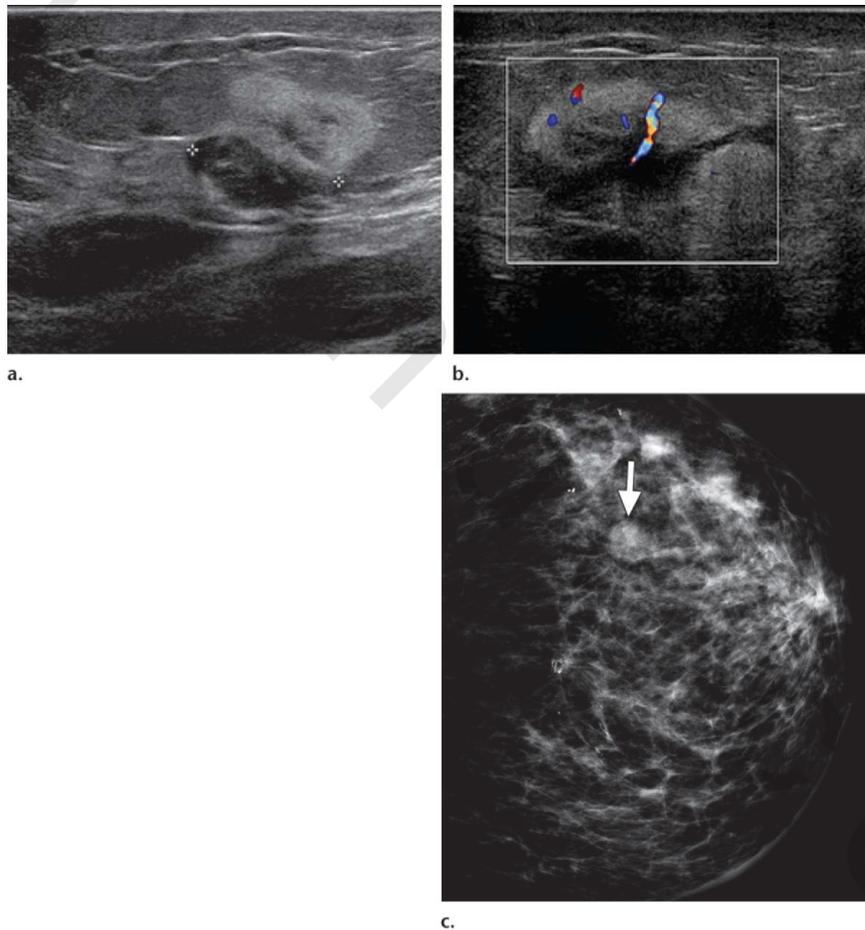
Angiosarcoma in a 64-year-old woman with a history of cancer in the left breast, lumpectomy, and radiation therapy who presented with an expanding “hematoma” in the left breast. (a, b) Gray-scale US (a) and color Doppler (b) images show a lobulated mass with mixed echogenicity (but predominantly echogenic) and internal vascularity. (c) CC mammogram shows a circumscribed, partially obscured mass (arrow). Biopsy demonstrated a high-grade sarcoma.⁽²⁹⁾
